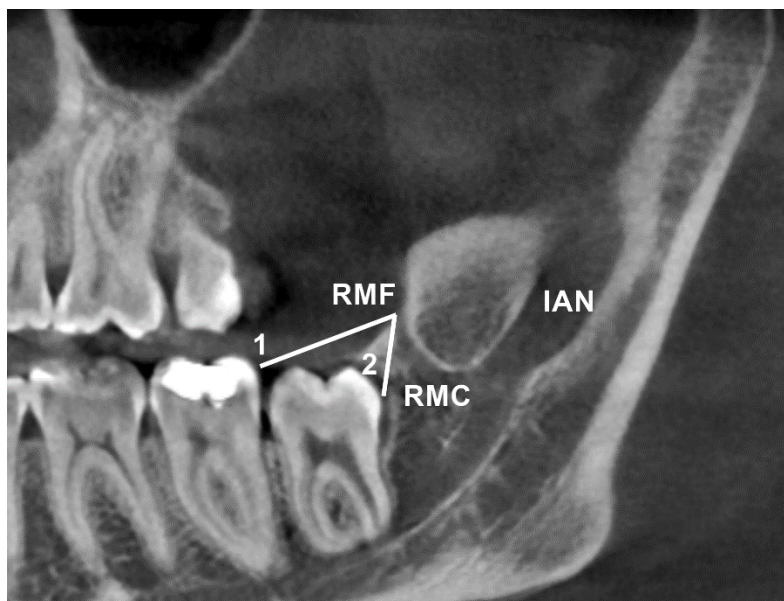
Sagittal CBCT image. RMC: the retromolar canal branching from the mandibular canal, IAN: inferior alveolar nerve, RMF: retromolar foramen, line 1: distance to the 2nd molar and line 2: distance to the 3rd molar.
